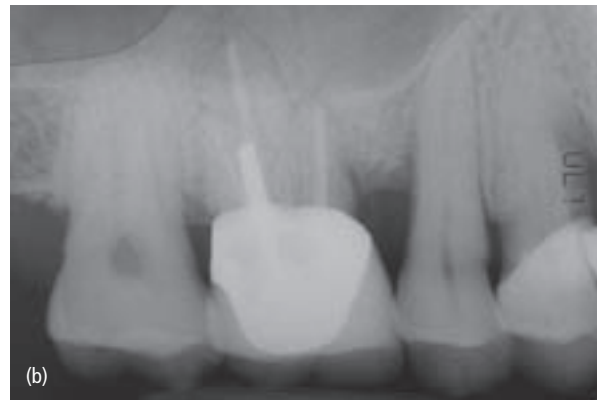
Periodontal therapy: chronology of failure. (a) Initial radiograph (1998) of teeth 4 and 5. (b) Radiograph, 2002. The bone level is stable. (c) Radiograph, 2004. The bone level has deteriorated on the distal of tooth 4. (d) Radiograph, 2006. There is too little bone left for implants. The patient needs guided bone regeneration before implant placement at sites 4 and 5.
